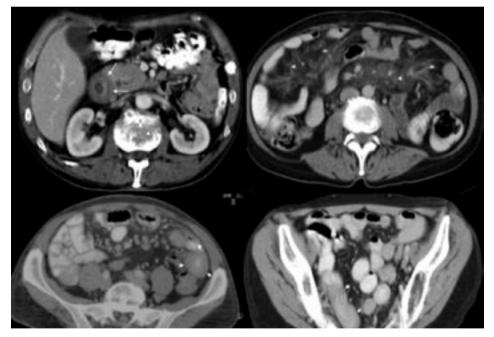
Axial CT images demonstrating abdominal EATL location. Figure 3a. duodenal localization of lymphoma (arrow). Figure 3b. Mesenterial localization showing "misty mesenterium" (*) and multiple lymph nodes Figure 3c. Jejunal localization of lymphoma (arrowhead) and multiple lymph nodes. Figure 3d. Ileal localization (arrowhead).
